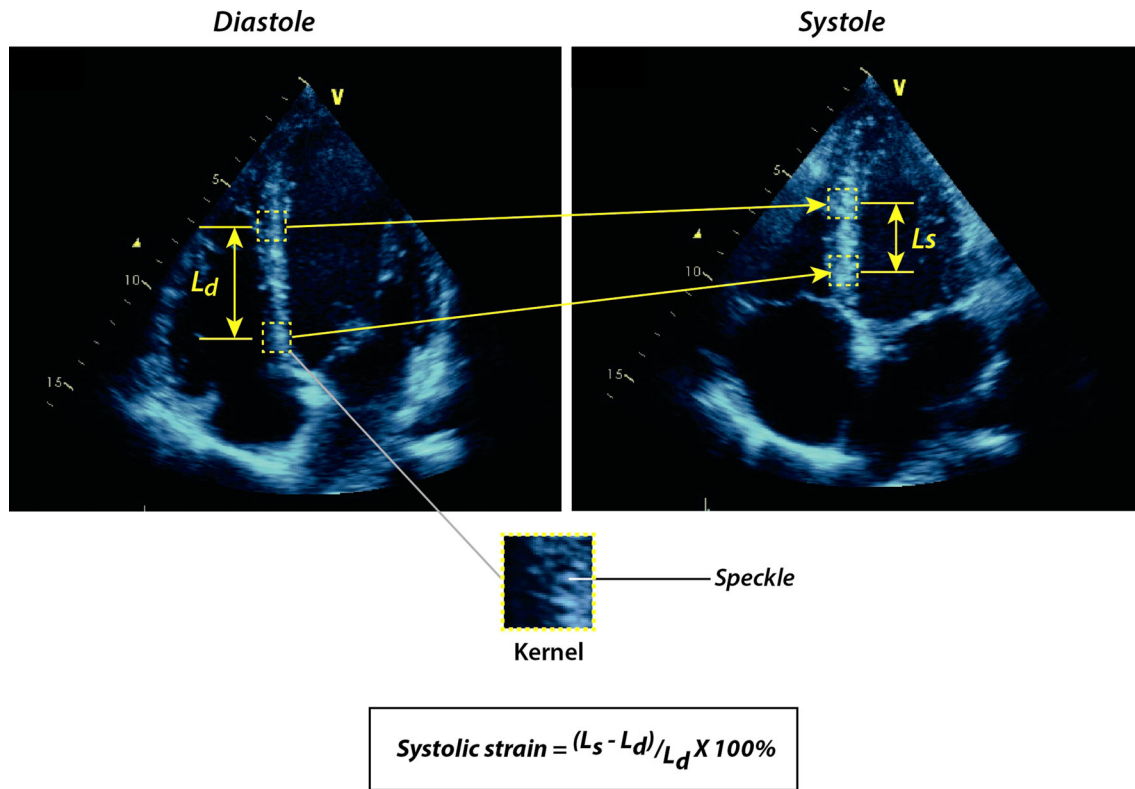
Left ventricular strain by speckle tracking echocardiography. “Speckles” are an ultrasound interference pattern of minute reflectors within the myocardium and do not represent real physical structures. Modern speckle tracking algorithm tracks the motion of a group of speckles, the kernel, frame by frame (*squares and magnified image*). The relative positions of the speckles within each
